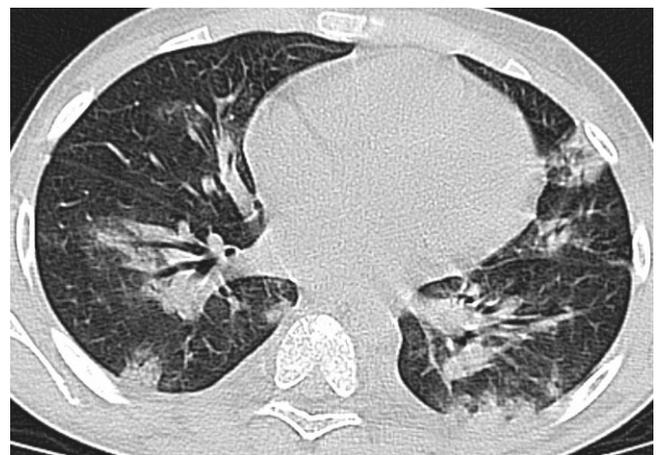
A 10-year-old boy with a confirmed diagnosis of H1N1. Computed tomography images performed 4 days after the onset of the symptoms demonstrate moderate peribronchovascular and subpleural consolidation predominant in the lower lobes. The boy developed respiratory failure and received mechanical ventilation for 19 days. The duration of viral shedding in this patient was 23 days, and he died 30 days after the onset of clinical symptoms.
